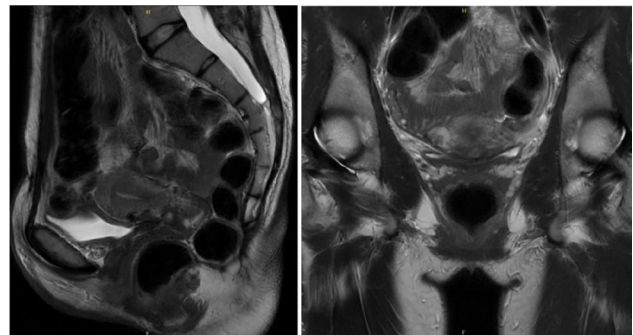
Post-operative MRI after three months of surgical intervention confirmed complete retrorectal tumor excision without any relapse.
